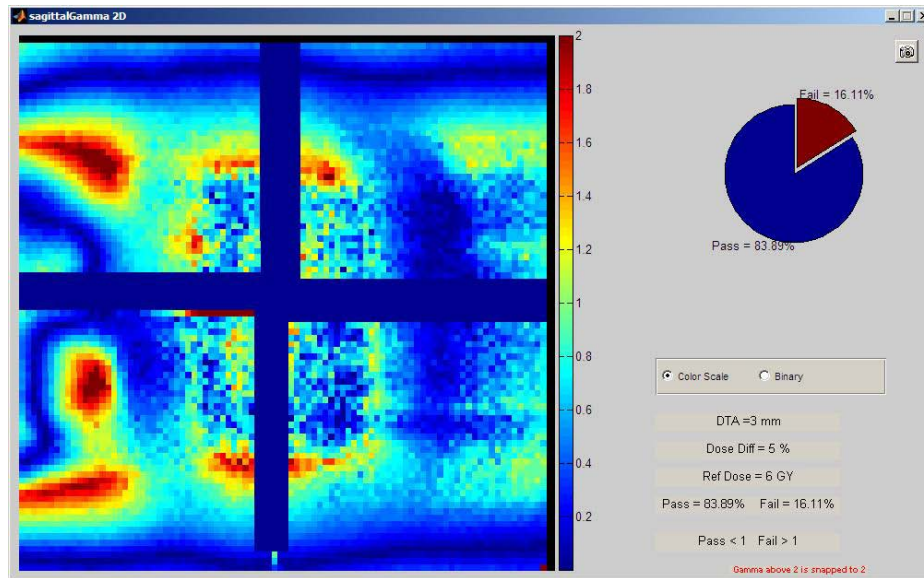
Plan 1a Trial 2 Sagittal Gamma Analysis with PVC Shell contoured and CT Number set to match Eclipse Calibration Curve
